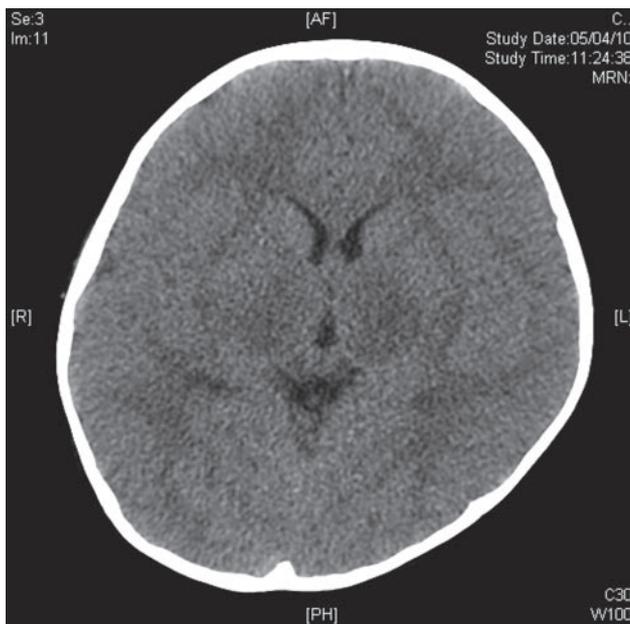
Plain CT brain performed on day 1 of presentation showed hypodense bilateral thalami.
